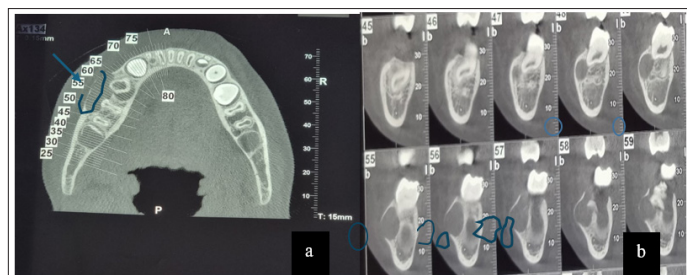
(a&b) : CBCT Scan showing the rupture of the External Bony Cortical as a Result to the Extension of the Cystic Lesion
